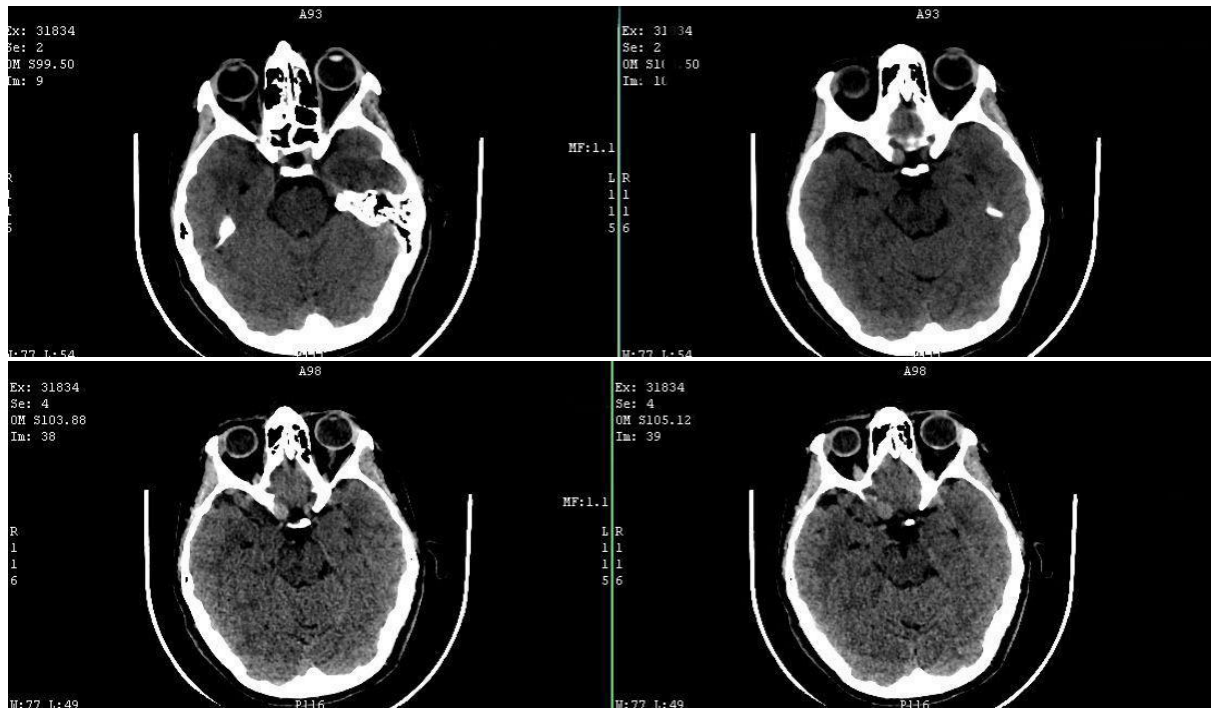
CT scan evaluation reveals an aneurysmal dilation in the right infra-cavernous internal carotid artery.
